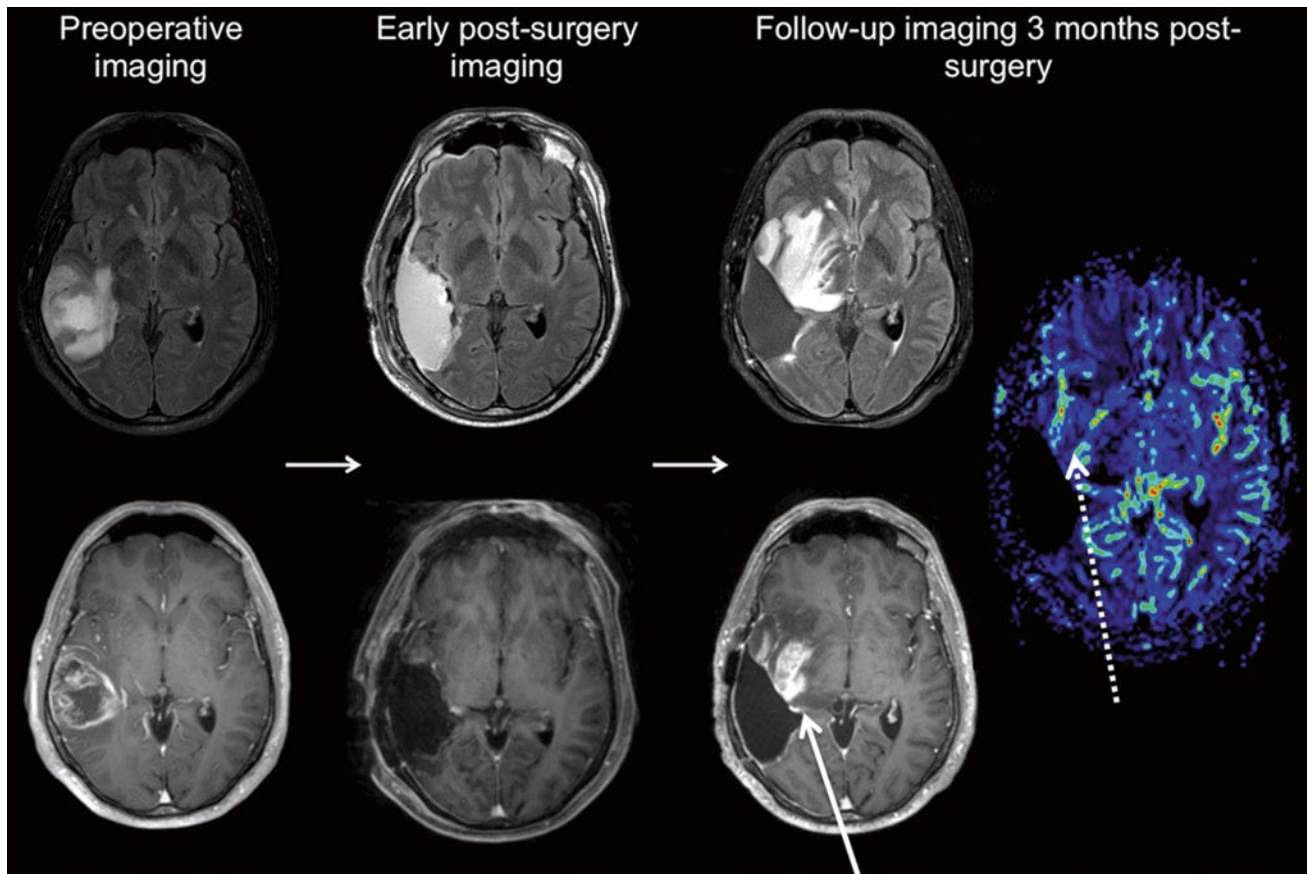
Imaging follow-up of another glioblastoma patient. Preoperative imaging (axial FLAIR and post-Gd T1w) shows—just like in Fig. 15—a partially necrotic tumor with infiltrating borders and contrast enhancement. Early postsurgery imaging (axial FLAIR and post-Gd T1w) shows no residual tumor. Follow-up at 3 months
